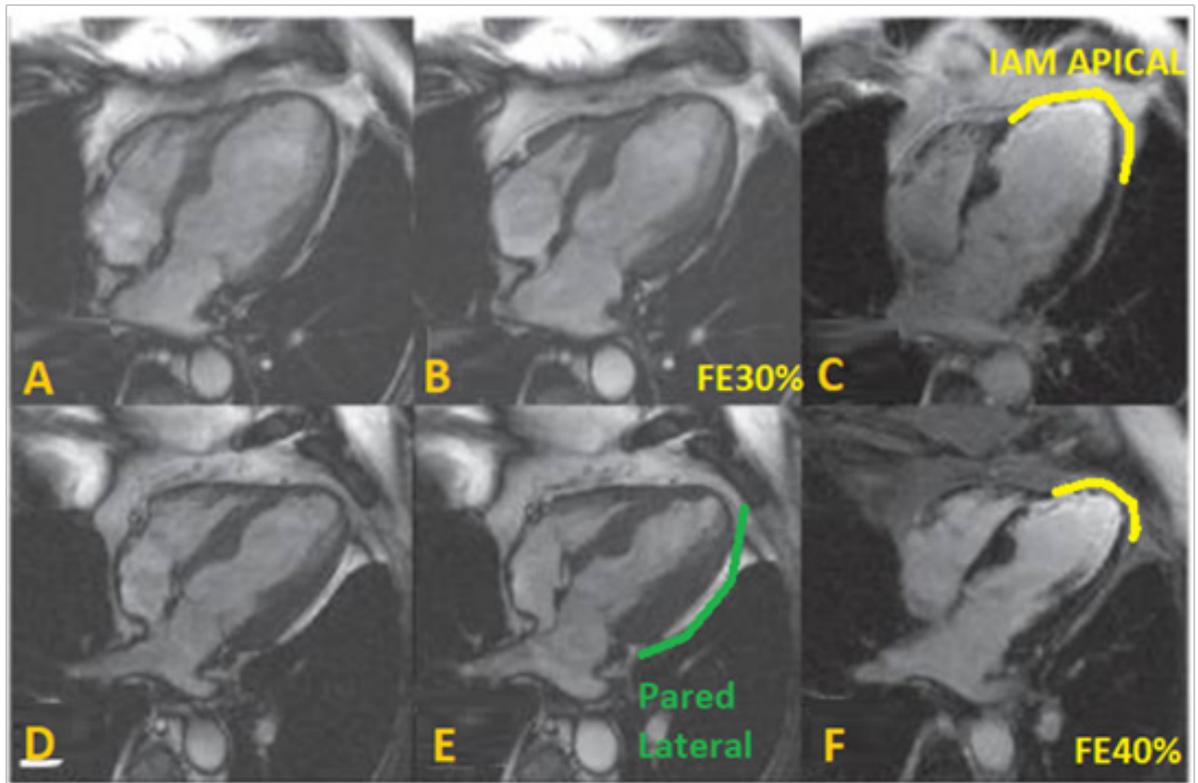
Adapted from Thielmann M et al. Magnetic resonance imaging in coronary artery bypass surgery – improvement of global and segmental function in patients with severely compromised left ventricular function by M Thielmann. *Vasc Health Risk Manag* (2007). Cardiac magnetic resonance imaging of a 64-year-old male patient before (upper line) and after (lower line) coronary revascularization. The end-diastolic (A) and end-systolic images (B) reveal a severe left ventricular systolic dysfunction before surgery (EF of 30%) that is akinetic in the inferior septal wall, apical anterolateral wall, and apical wall, and hypokinetic in the lateral basal and mid wall. The image in (C) shows wide late subendocardial enhancement (bright signal) in the apical septum, thin in the lateral wall, and transmural in the apex indicative of chronic scar. The left ventricular function after surgery (D, E) does not show an improved apical septum or apex while the entire lateral wall actually improved and turned normokinetic. No changes were seen on the spread of the scar (F). The global left ventricular function improved with an EF of 40% while left ventricular volumes decreased.
